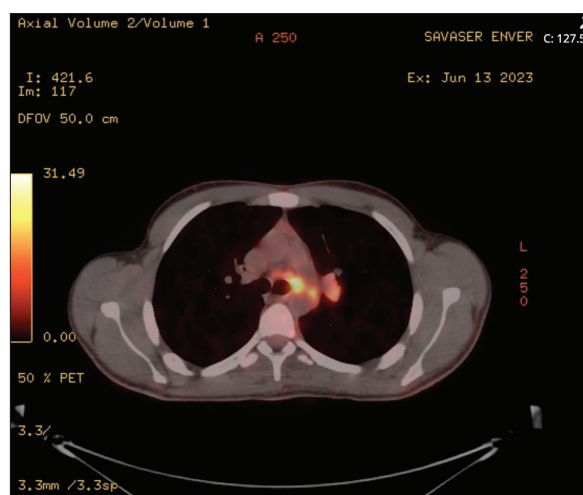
PET CT shows increased ^{18}F -FDG uptake in lymph nodes in the mediastinum and left hilar region.
